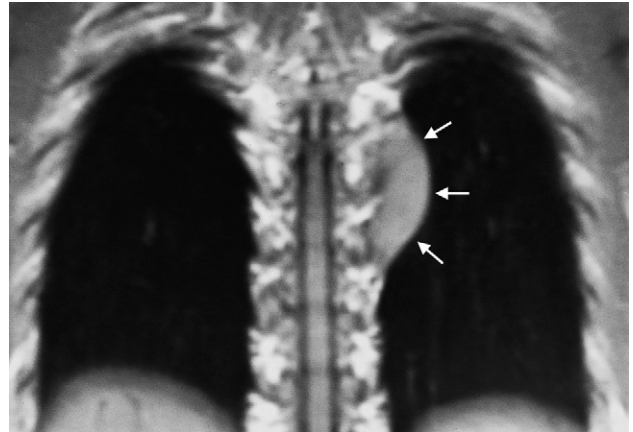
Neurofibroma in the posterior mediastinum. MRI showing the neurofibroma (arrows) lying against the spine, but not growing into the spinal canal.
